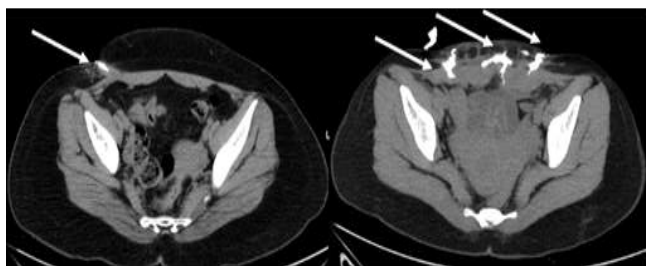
Figure depicting extraperitoneal and intraperitoneal extension on CT Sinusogram
